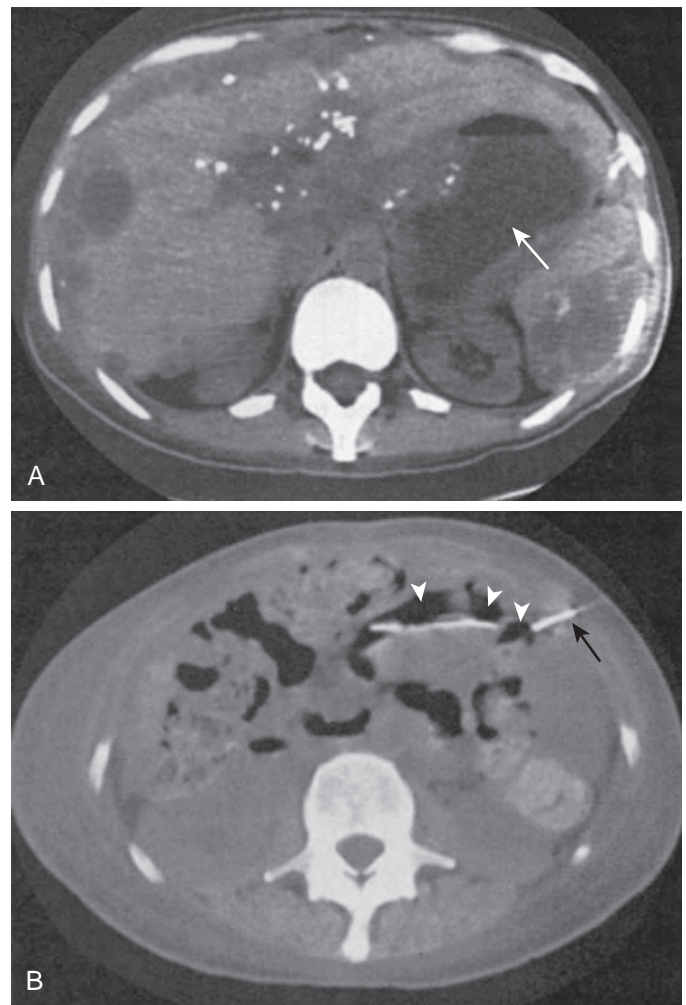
CT-guided percutaneous gastrostomy. A. CT scan of the upper abdomen in a patient with pseudomyxoma peritonei attributable to ovarian carcinoma shows the stomach (arrow) surrounded by adjacent organs and peritoneal metastases. B. At a more caudal level, a safe window to the stomach is present. Percutaneous gastrostomy was successfully performed under CT guidance. Arrowheads, Gastric lumen; black arrow, initial puncture needle.
